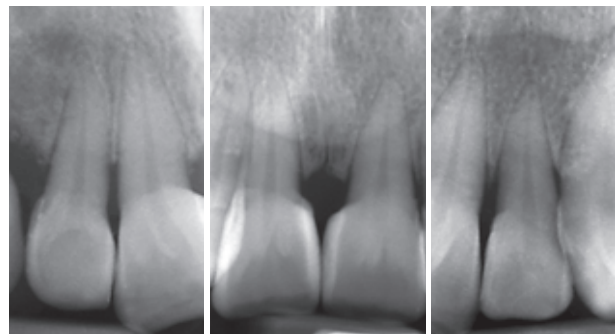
Radiographs after treatment.
